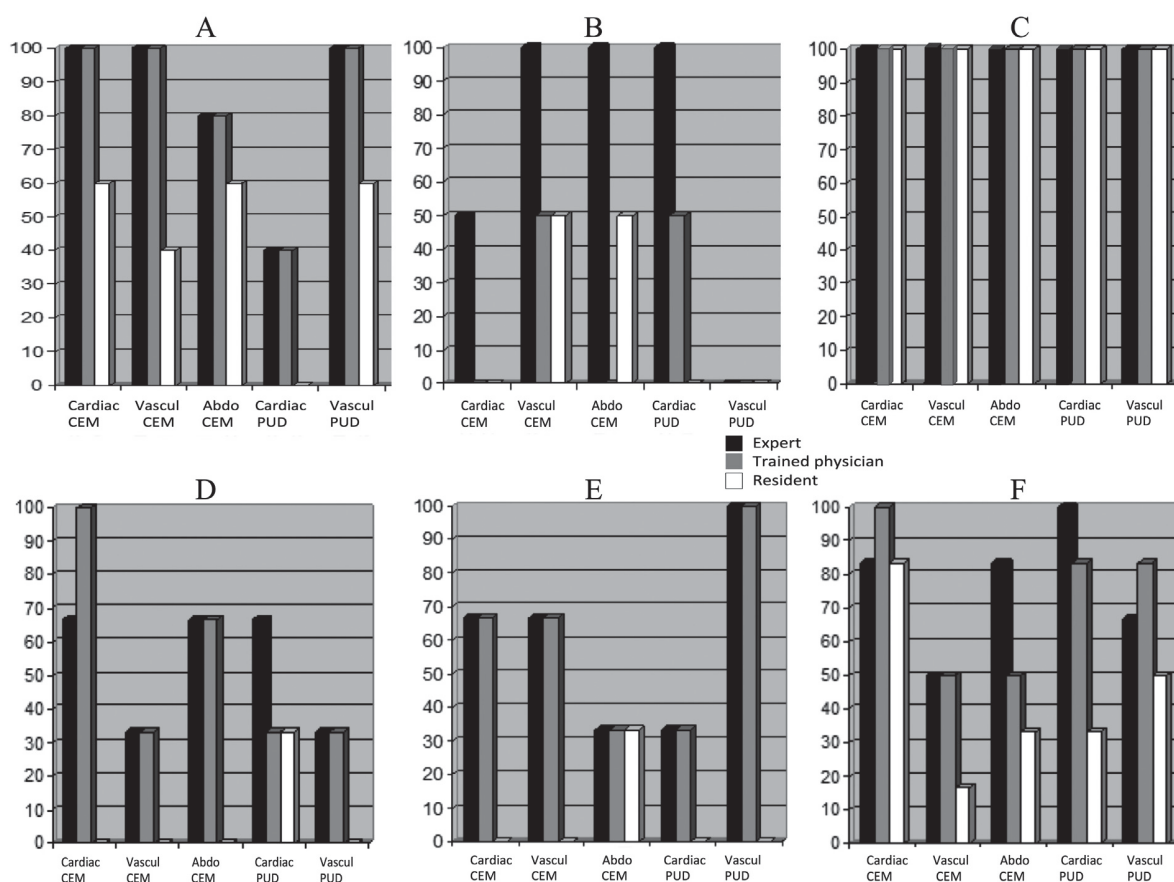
Comparison of ultrasound probes for the diagnosis of various lung ultrasound syndromes. A: Diagnosis of normal lung; B: diagnosis of pulmonary consolidation; C: diagnosis of pleural effusion fluid; D: diagnosis of association of pulmonary consolidation with pleural effusion fluid; E: diagnosis of pneumothorax; and F: diagnosis of alveolo-interstitial syndrome (AIS). Black bar: blinded expert operator; grey bar: trained operator; white bar: resident. CEM: conventional echo machine; PUD: pocket ultrasound device; Cardiac: cardiac transducer; Vascul: vascular transducer. Abdo: abdominal transducer.
